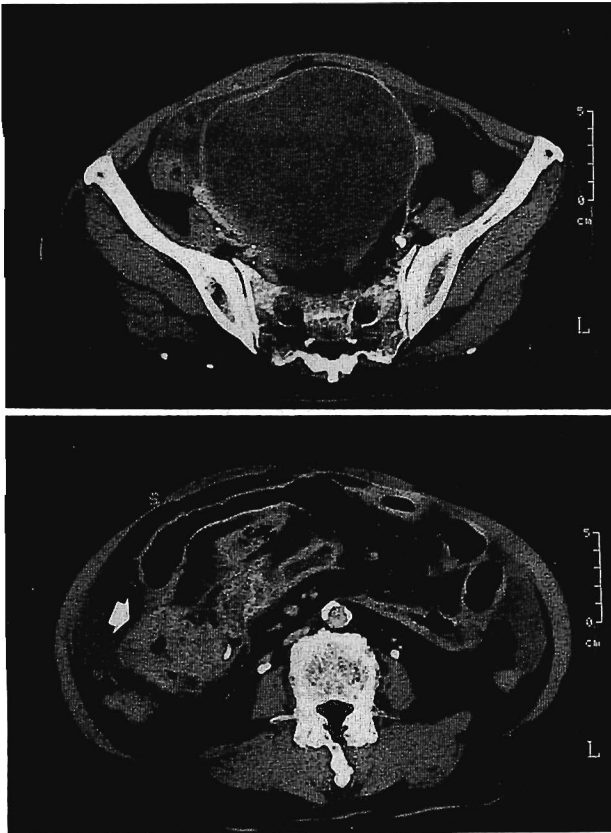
Abdominal CT showing a huge cystic mass (pyometra) in the pelvic cavity (top) and a heterogeneous dense mass with a dotted calcification (arrow) in the ileocecal region (bottom).
